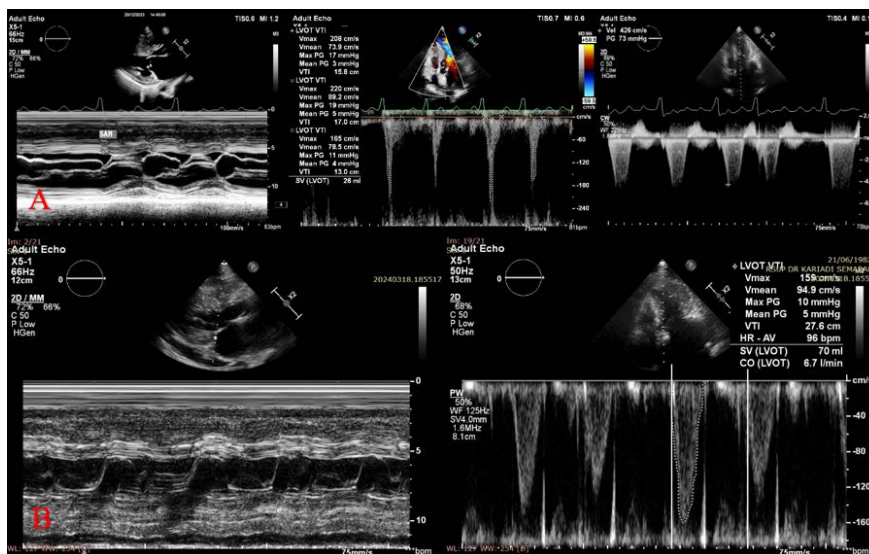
(A) Echocardiographic finding of case 1 with SAM (+) and dynamic LVOTO with LVOT peak gradient during resting (19 mmHg) and Valsava manuever (73 mmHg) and (B) case 2 with SAM (-) and resting LVOT peak gradient (10 mmHg)
